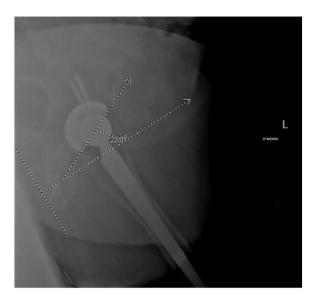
Six-month postoperative AP radiograph of the pelvis revealing appropriate cup anteversion of 23.8 degrees.
